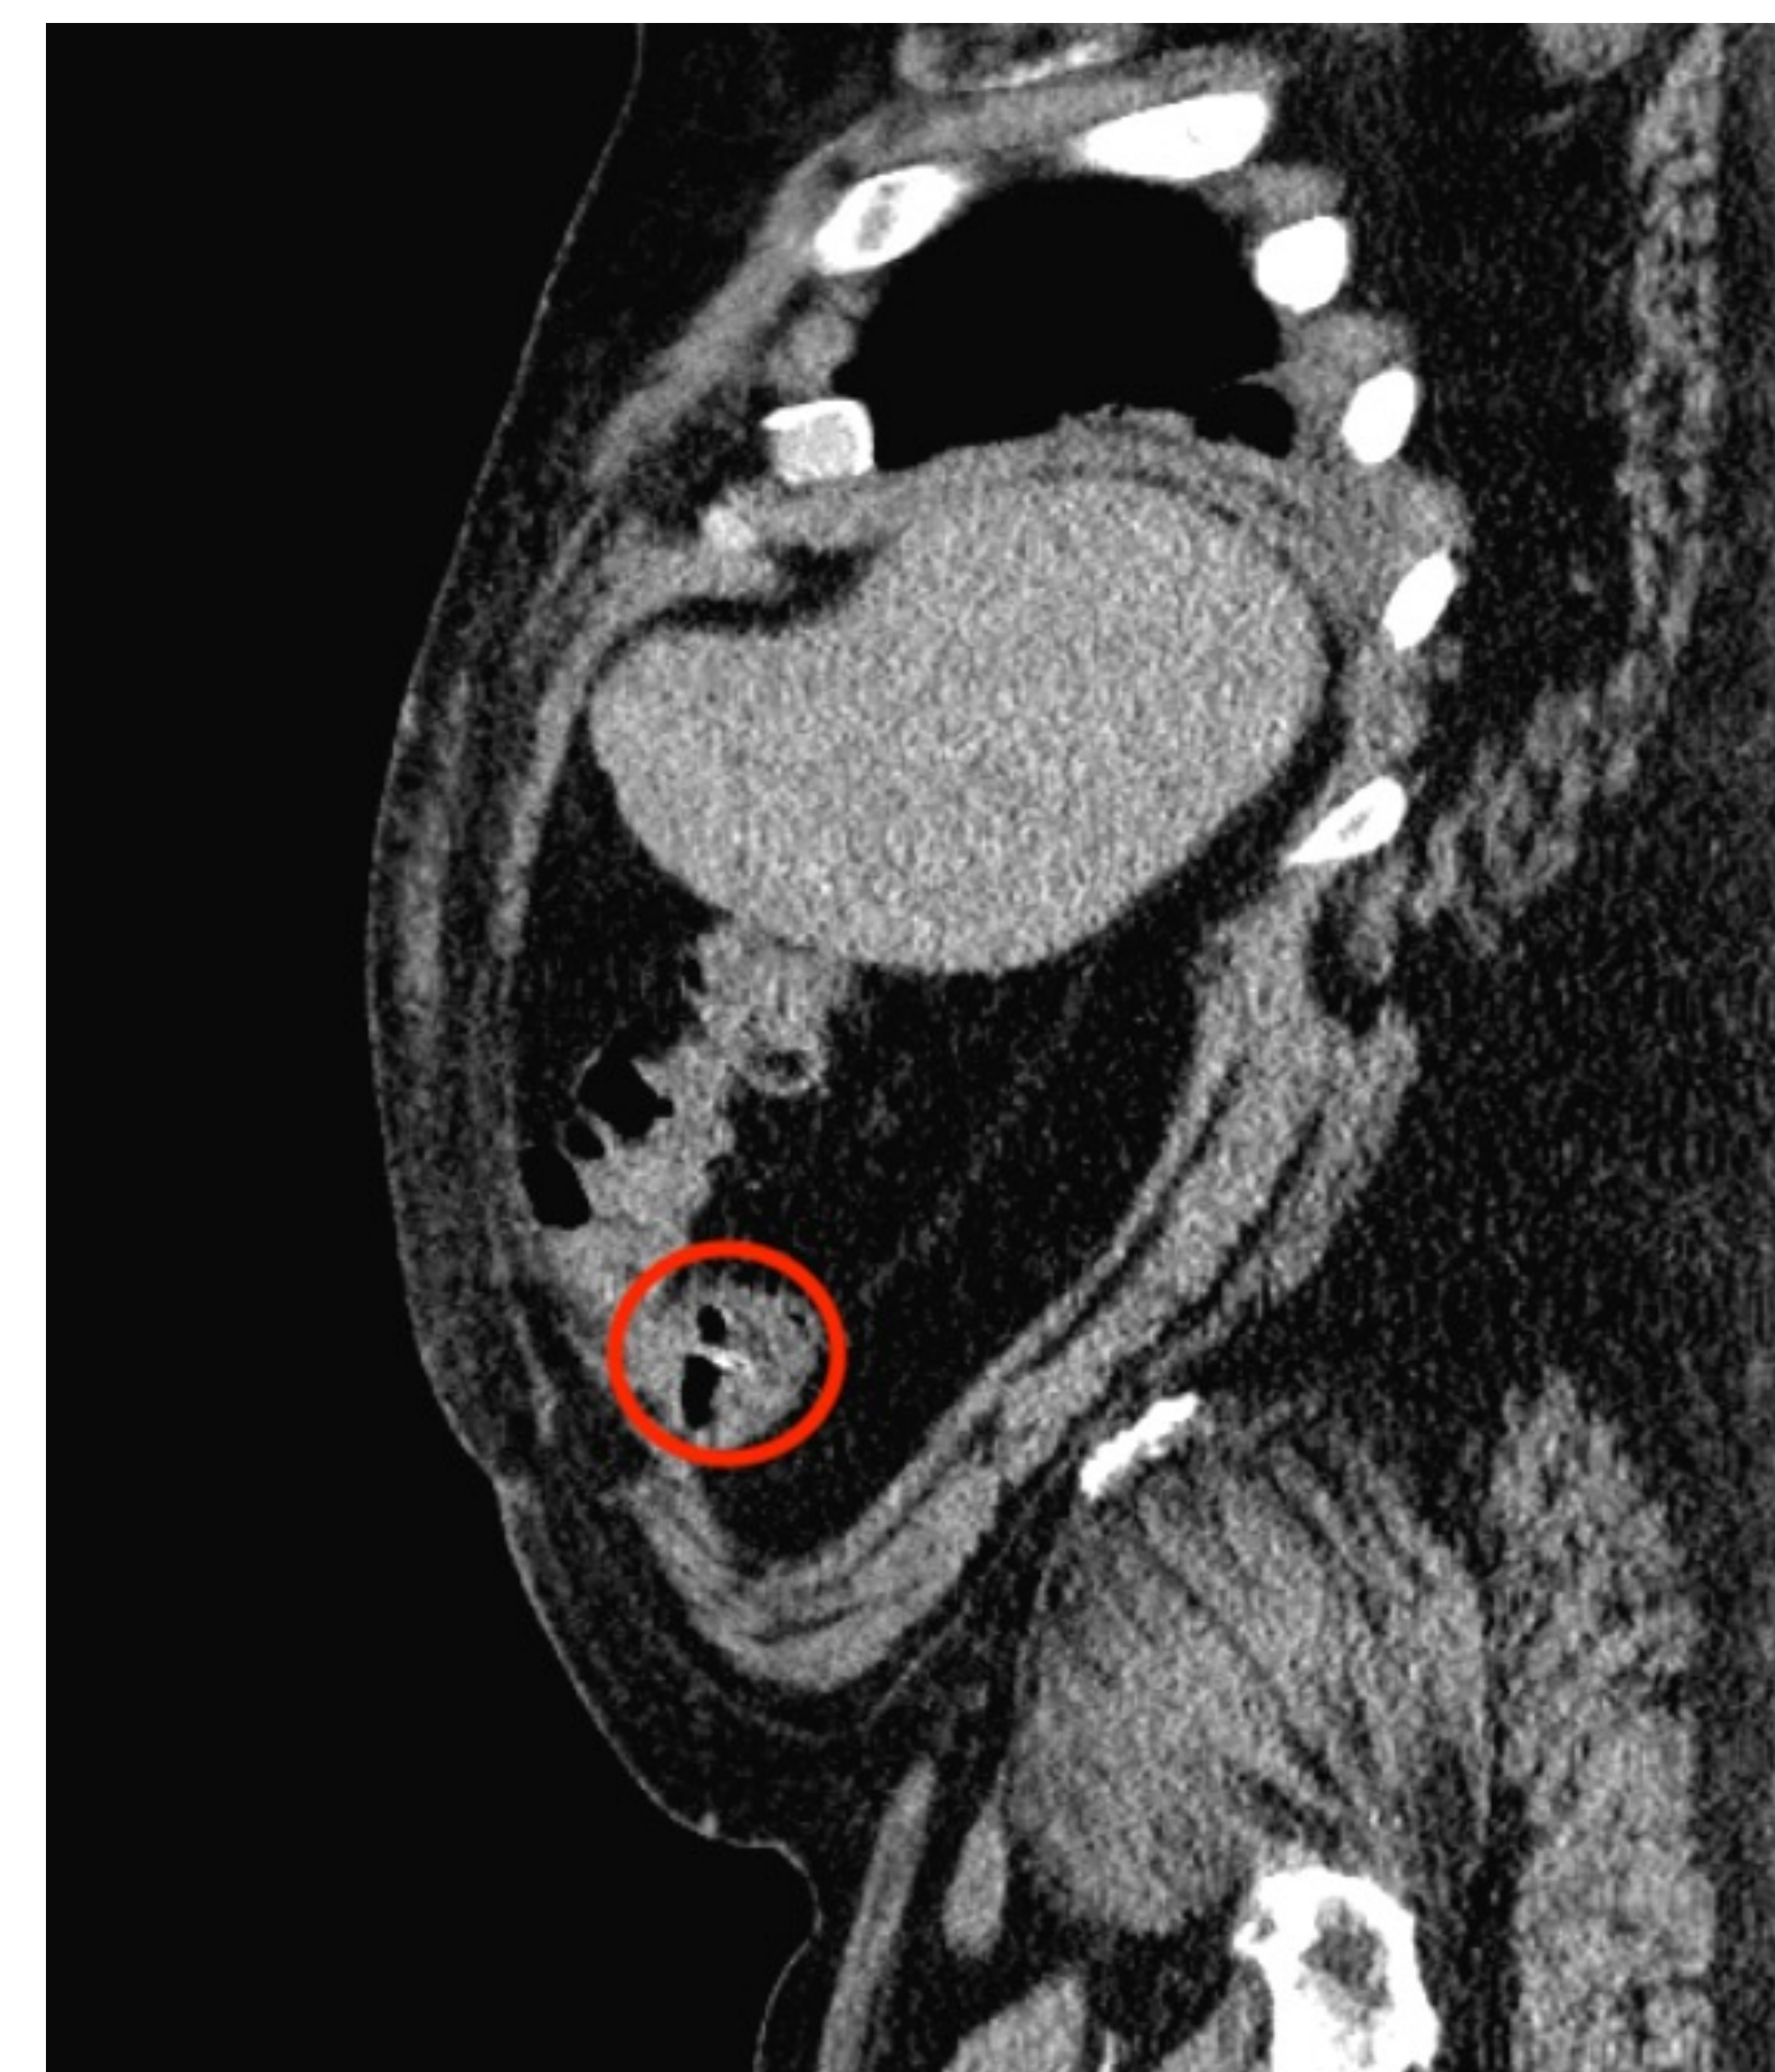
Sagittal CT scan of the abdomen showing a foreign body in the cecum (red circle).
